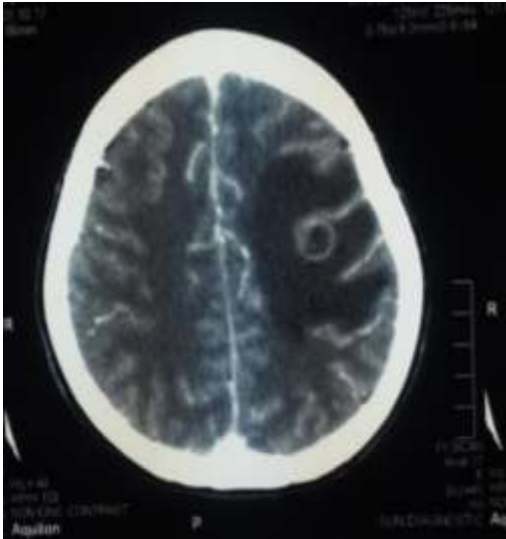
CT scan of brain showing a ring enhancing lesion in the right temporal lobe involving the gangliocapsular region with perilesional edema, mass effect and midline shift to left.
